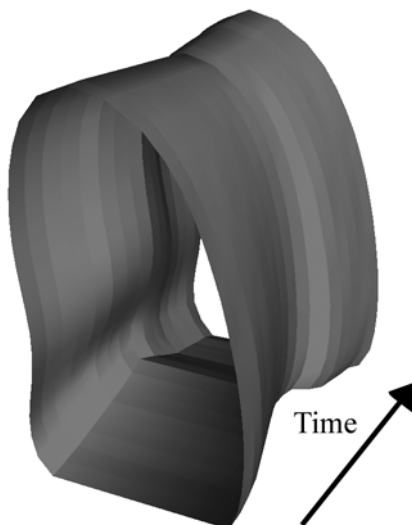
Motion of the left ventricular endocardium in ultrasound four-chamber cross section represented as a 3-D object. Time axis from bottom left to top right.
